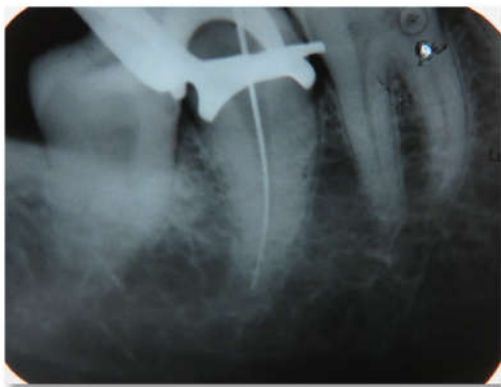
b Working length radiograph
